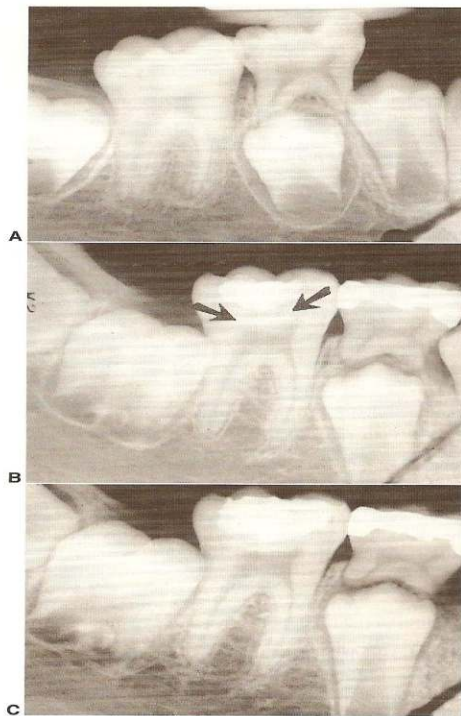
A, Radiograph of the first permanent molar revealed a deep carious lesion. Gross caries was removed, and calcium hydroxide was placed over the remaining caries. The tooth was restored with amalgam and was not reentered for complete caries removal for 3 months. B, Sclerotic dentin can be seen beneath the remaining caries and the covering of calcium hydroxide (arrows). C, The tooth was reentered, and the remaining caries was removed. A sound dentin barrier was observed at the base of the cavity. A new amalgam restoration was placed after complete caries removal.
